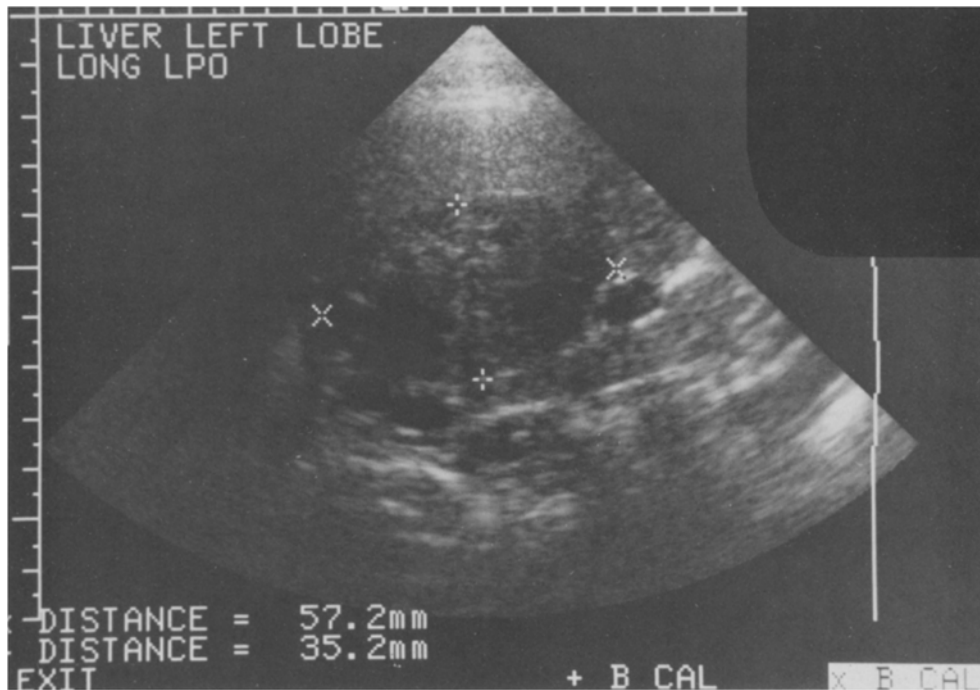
Ultrasound examination of hepatic mass shows a generally hypoechoic lesion with some scattered internal echoes.
